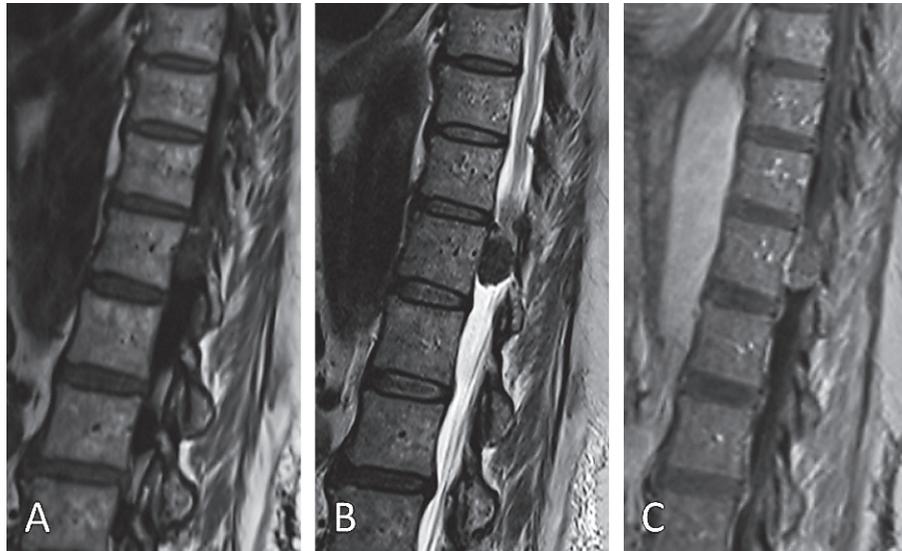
T1-weighted (A) and T2-weighted (B) sagittal MR images showing homogeneous low signal intensity within the spinal canal at T12 in the patient, a 61-year-old woman. Postcontrast T1-weighted MRI (C) showing a heterogeneously enhanced tumor.
